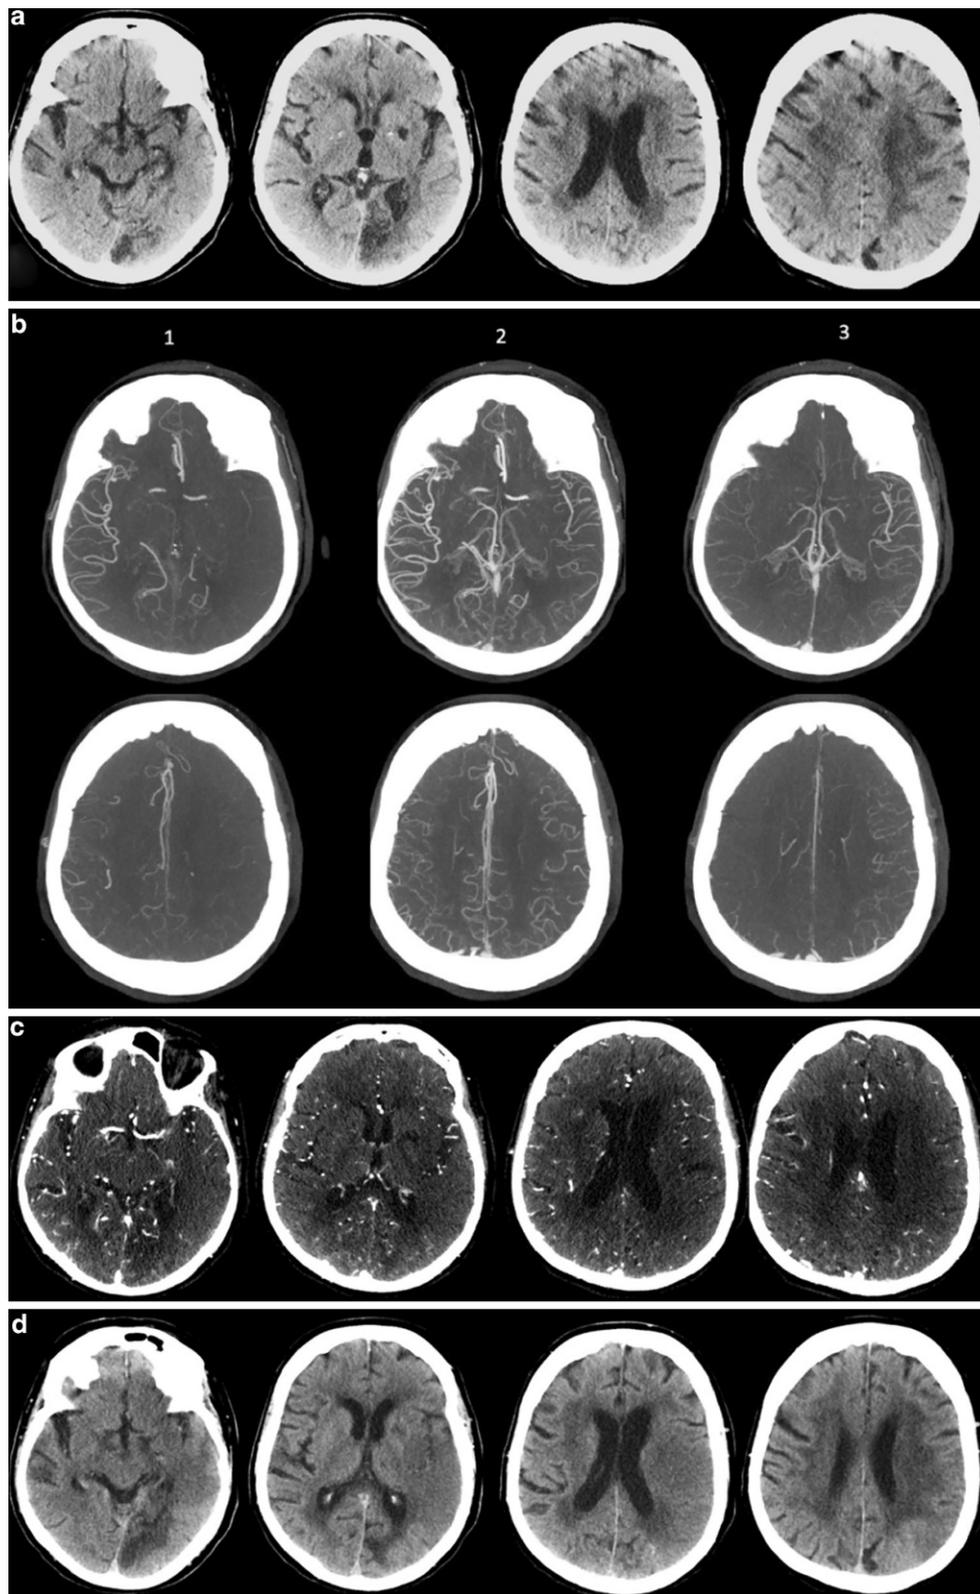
A 91-year-old female patient with left distal M1 occlusion which was reperused (TICI-2b) at 45 min after admission CT. Patient had a baseline mRS of 0 and a 90-day mRS of 6 (deceased). a NCCT-ASPECTS = 10. b The three numbered phases of mCTA-rLMC = 14. c mCTA-venous = 3. d 24-h CT ASPECTS = 3
